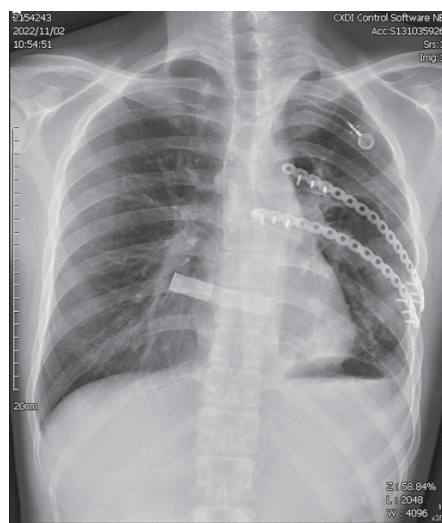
Chest X-ray during follow-up at the OPD.
